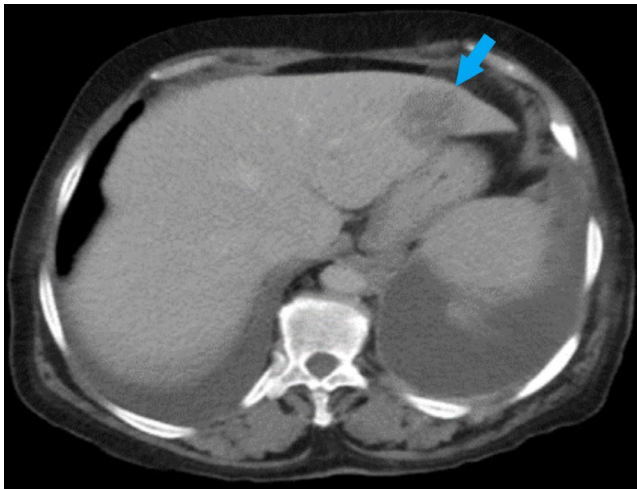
Axial upper abdomen CT shows segment II hepatic metastasis (blue arrow)
